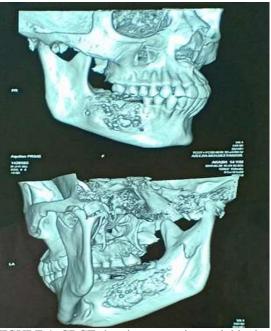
CBCT showing expansion and thinning of right hemi mandible with well defined central sclerotic area and areas of cortical breach
